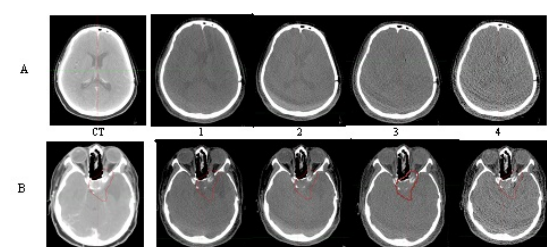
CT planning scan (CT) at the level of the ventricles and ROI (A-B) and corresponding CBCT templates 1-2-3-4 demonstrating the change in discernibility of selected structures with imaging templates.
